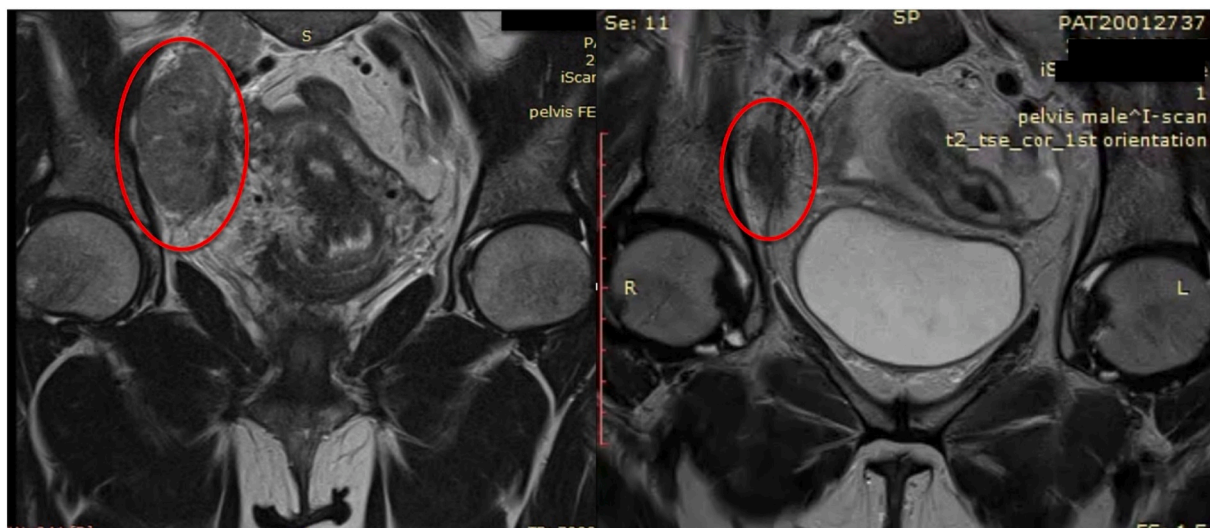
Magnetic resonance imaging showing the right iliac node before and after neoadjuvant treatment. (a) A confluent enlarged right external iliac, internal iliac and common iliac nodes largest $4.5 \times 2.5 \times 5.6$ cm pre-neoadjuvant treatment. (b) A decrease in size of the confluent right lateral lymph nodes now measuring 1.3×0.9 cm after neoadjuvant treatment.
